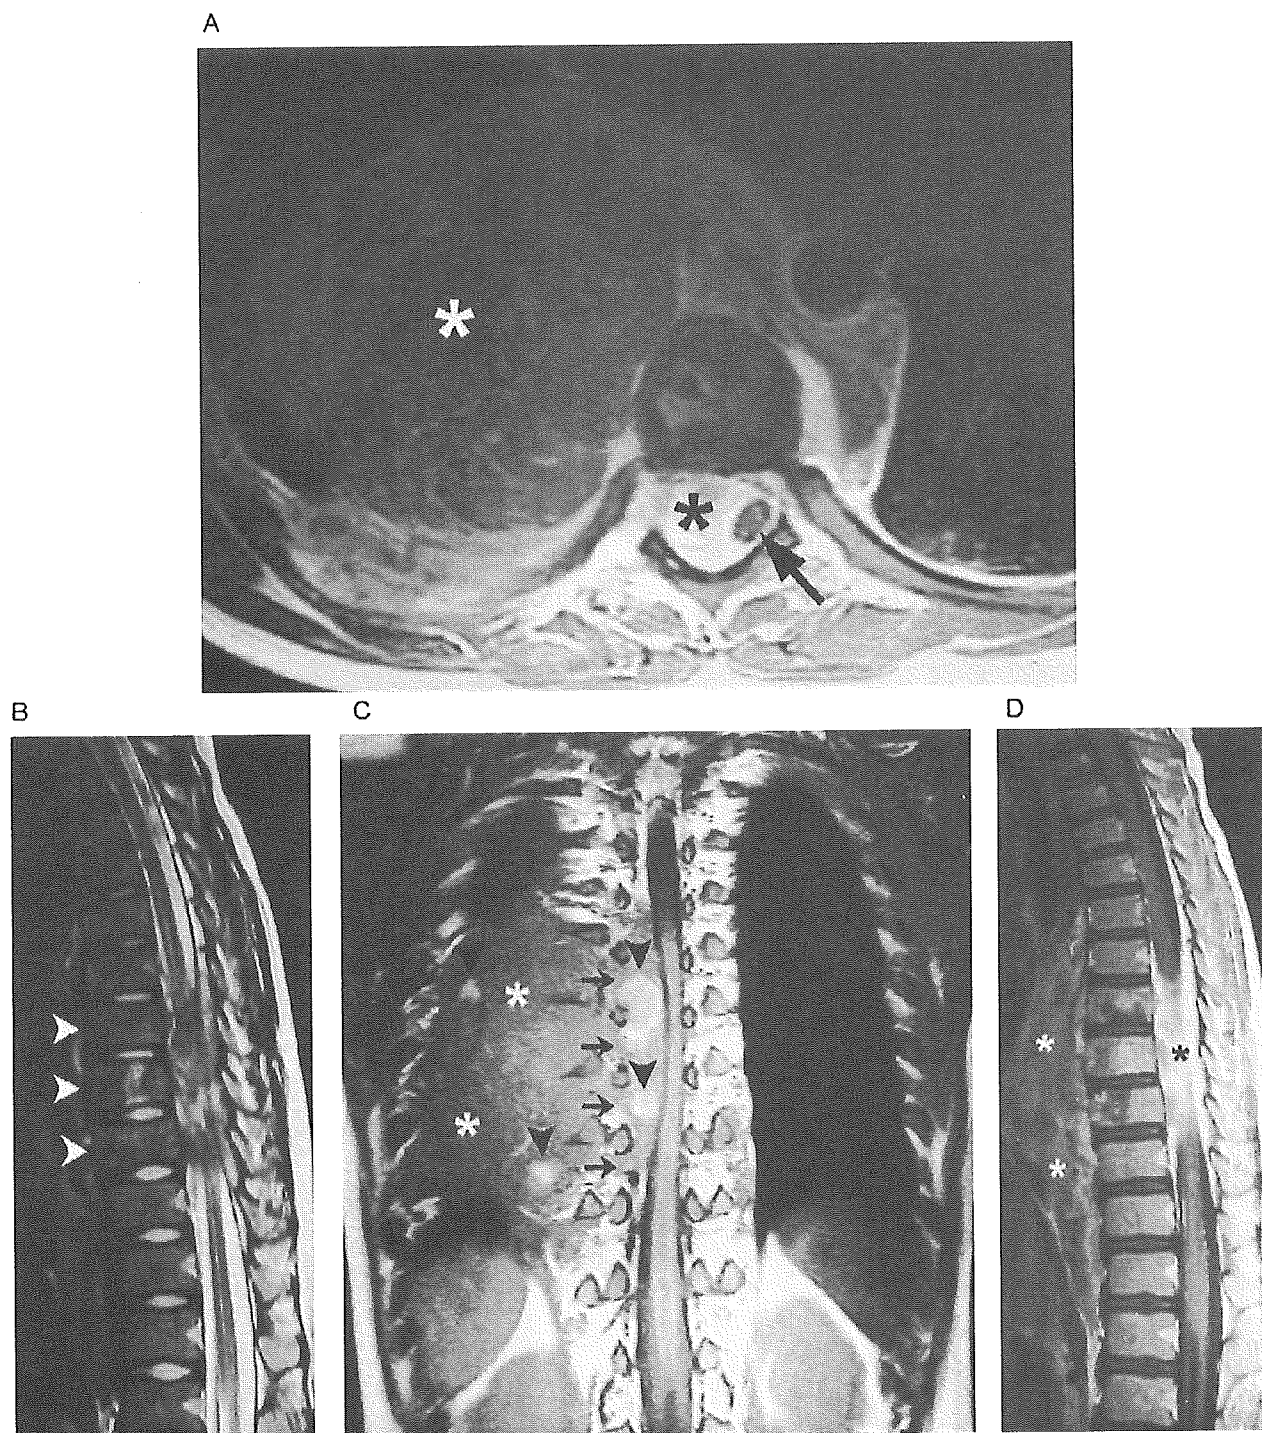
Thoracic neuroblastoma with intraspinal invasion in a 6-year-old boy. (A) Coronal T1-weighted image. (B) Sagittal T2-weighted image. (C) Gd-enhanced sagittal T1-weighted image. (D) Axial gd-enhanced axial T1-weighted image. Huge thoracic mass (black asterisks, A–D) extends an intraspinal component through four, markedly enlarged neural foramina (arrows, A). This component, hypointense on T2-weighted images (B) and enhancing with contrast material administration (black asterisk, C,D), compresses and engulfs the spinal cord (arrow, D). The mass has numerous hemorrhagic components (arrowheads, A). Three pathologic vertebrae are seen (arrowheads, B).
